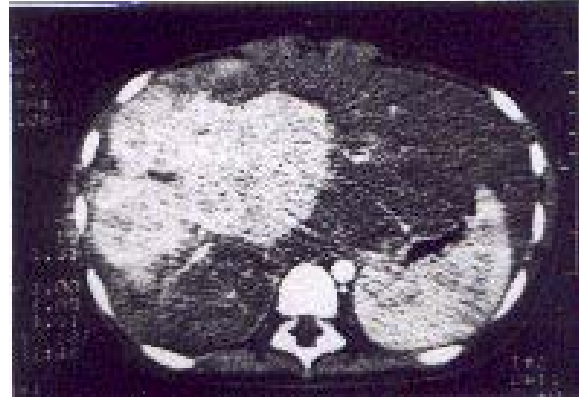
Contrast-enhanced computed tomography of abdomen showing intense enhancement of hepatic lesions during arterial phase
